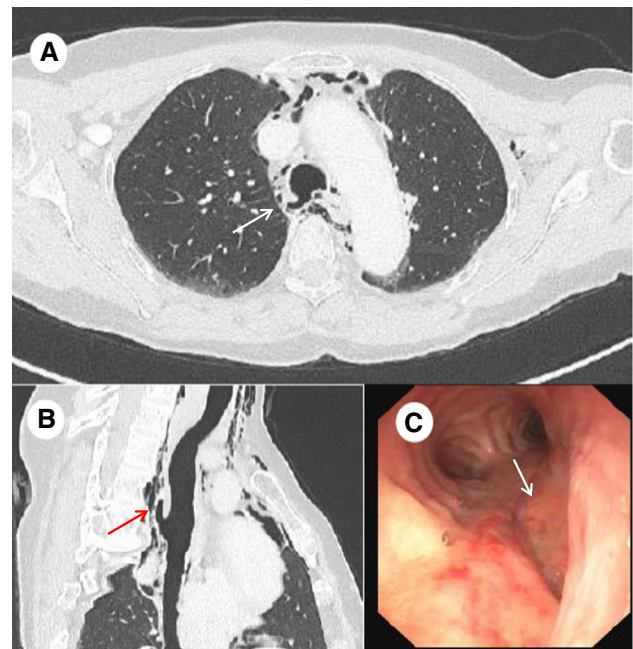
Figure Transverse (A) computed tomography (CT) image of the distal trachea showing pneumomediastinum and a small (7 × 2 mm), air-filled protrusion (white arrow) of the right posterolateral tracheal wall 3 cm above the carina. The corresponding sagittal CT image (B) shows the posterosuperior location of the diverticulum (red arrow). The bronchoscopic view of the carina (C) shows the outpouching of the right posterolateral distal membranous tracheal wall
